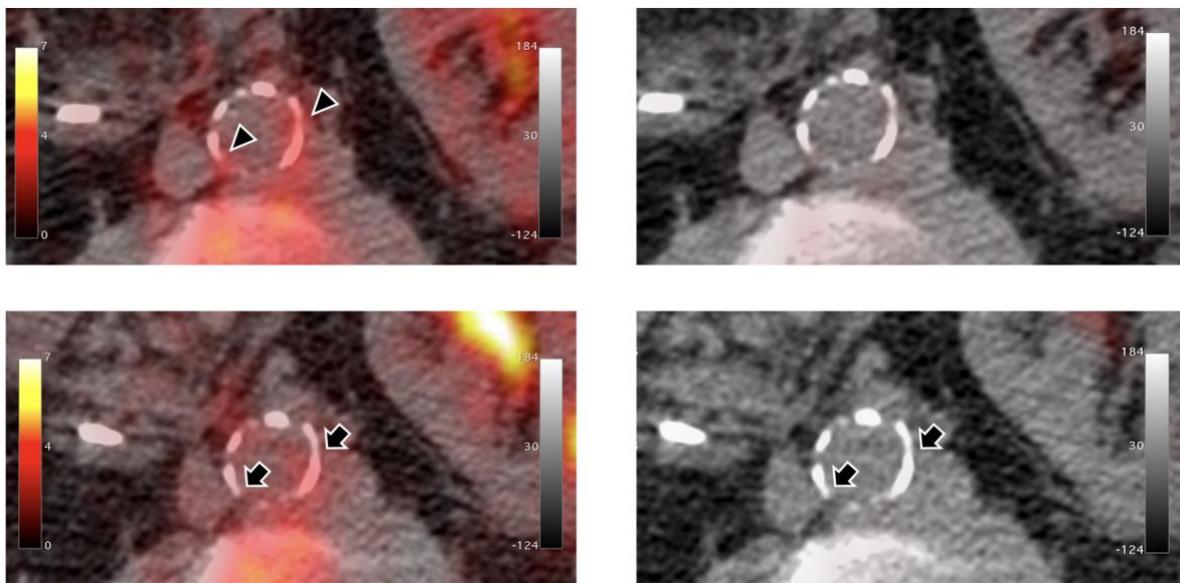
Mixed-type plaque. Notice the focal increased NaF uptake at the baseline PET (top left panel, arrowheads). In the same positions, increase in calcium content is observed and the gap between the two plaques on the left side of the aorta is closed (bottom left panel, arrows). The right panel show the CT images.
